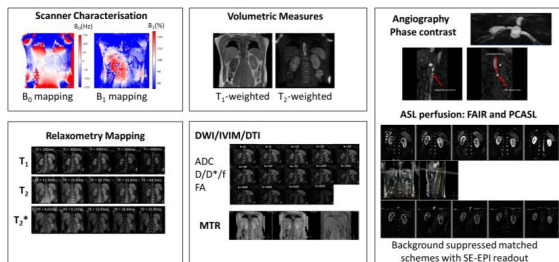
The multiparametric UKRIN-MAPS protocol, comprising B_0 and B_1 mapping, relaxometry (T_1 MOLLI and Inversion recovery SE-EPI, ME-SE T_2 and BOLD R_2^*/T_2^*), Diffusion Weighted Imaging, angiograms and phase contrast MRI, magnetization transfer ratio mapping, volumetric T_1 - and T_2 -weighted scans, mDIXON, and ASL perfusion scans.
